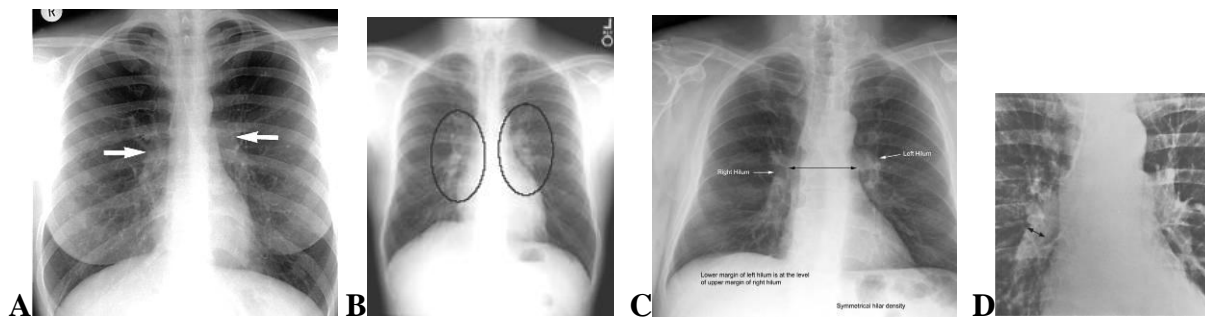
Normal hilar anatomy. (A to C) Normal PA chest radiograph demonstrating position and density of the hilar structures. Arrows indicate the hilus points, where the superior pulmonary vein crosses the descending lower lobe artery, the left normally being level with or slightly higher than the right. (D) Frontal view of hila in plain chest radiograph. The measurement points for the diameter of the right lower lobe artery are indicated
